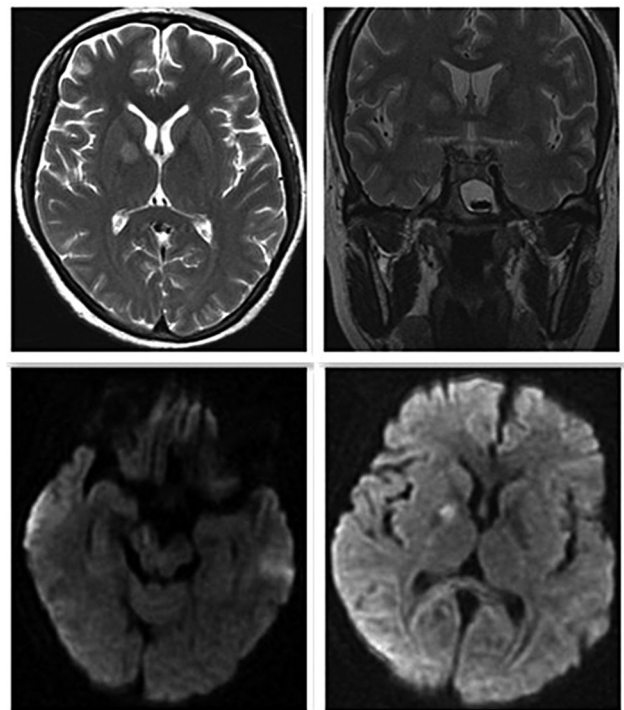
Head MRI showing long T1 and T2 signals with diffuse punctuates, and high signal intensity on DWI.
